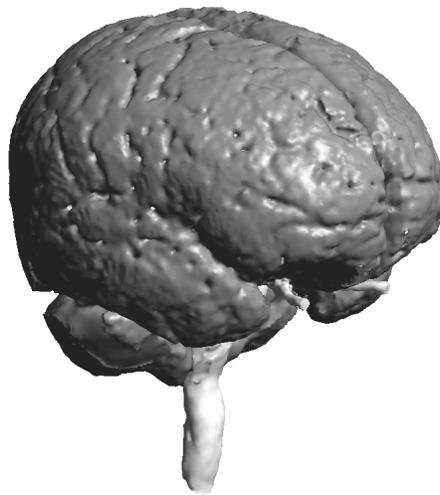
3D model of brain surfaces in Gmsh created by processing 5-7 year old patient-derived MRI scans in SimNIBS 4.5.0.
